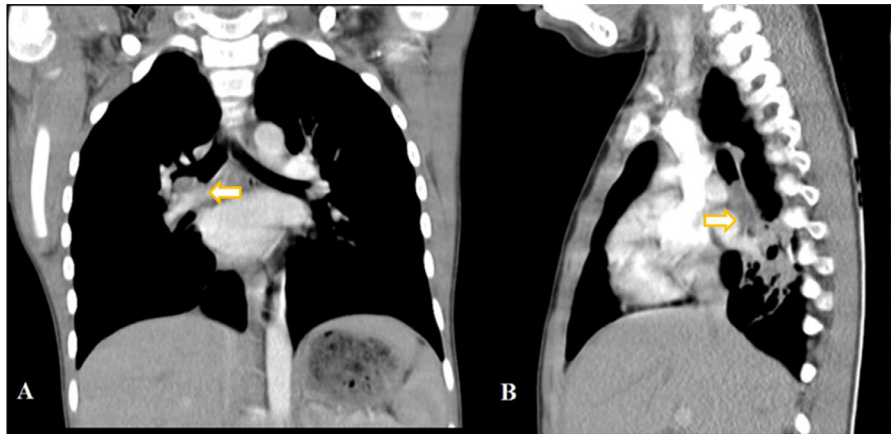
Chest CT scan. (A) Coronal view shows a mass lesion in the right bronchus. (B) Sagittal view also shows the mass and associated atelectasis. Arrows are shown the intrabronchial mass.
